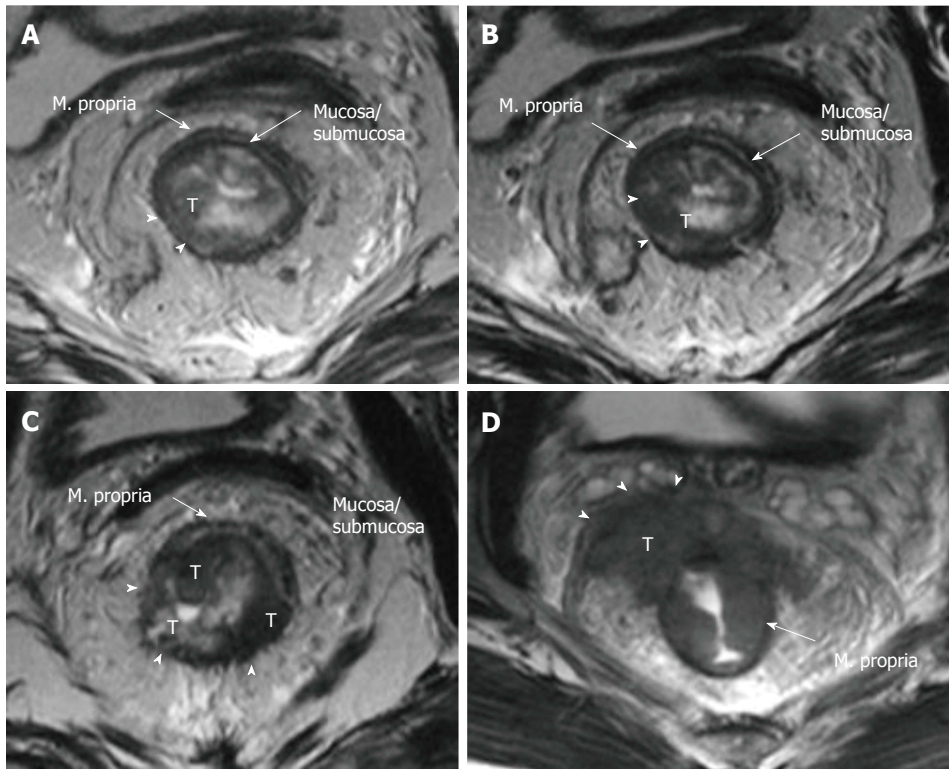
Rectal cancer T staging on magnetic resonance imaging. T2-weighted axial images showing rectal carcinomas with different T stages. A: T1 tumor is confined to the submucosa, has not entered the muscularis propria (arrowheads); B: T2 tumor extends into, but not beyond, the muscularis propria (arrowheads); C: T3 tumor extends beyond the muscularis propria and strands into mesorectal fat (arrowheads); D: T4a tumor invades the visceral peritoneum (arrowheads). T: Tumor.
